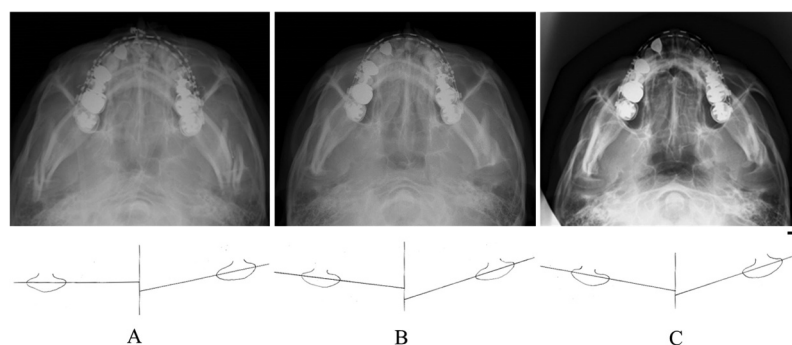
Post-operative changes in condylar position over time on axial cephalometric radiographs (age of patient). Each scheme indicates condylar long axis angle (°) to A-P midline. (A) Immediately after IVRO (24 years 10 months): Rt 91 (°), Lt 76 (°). 4 months later (25 years 2 months): Rt 86 (°), Lt 74 (°). (C) 1 year later (25 years 10 months): Rt 80 (°), Lt 73 (°). Scale bar means 10 mm.
